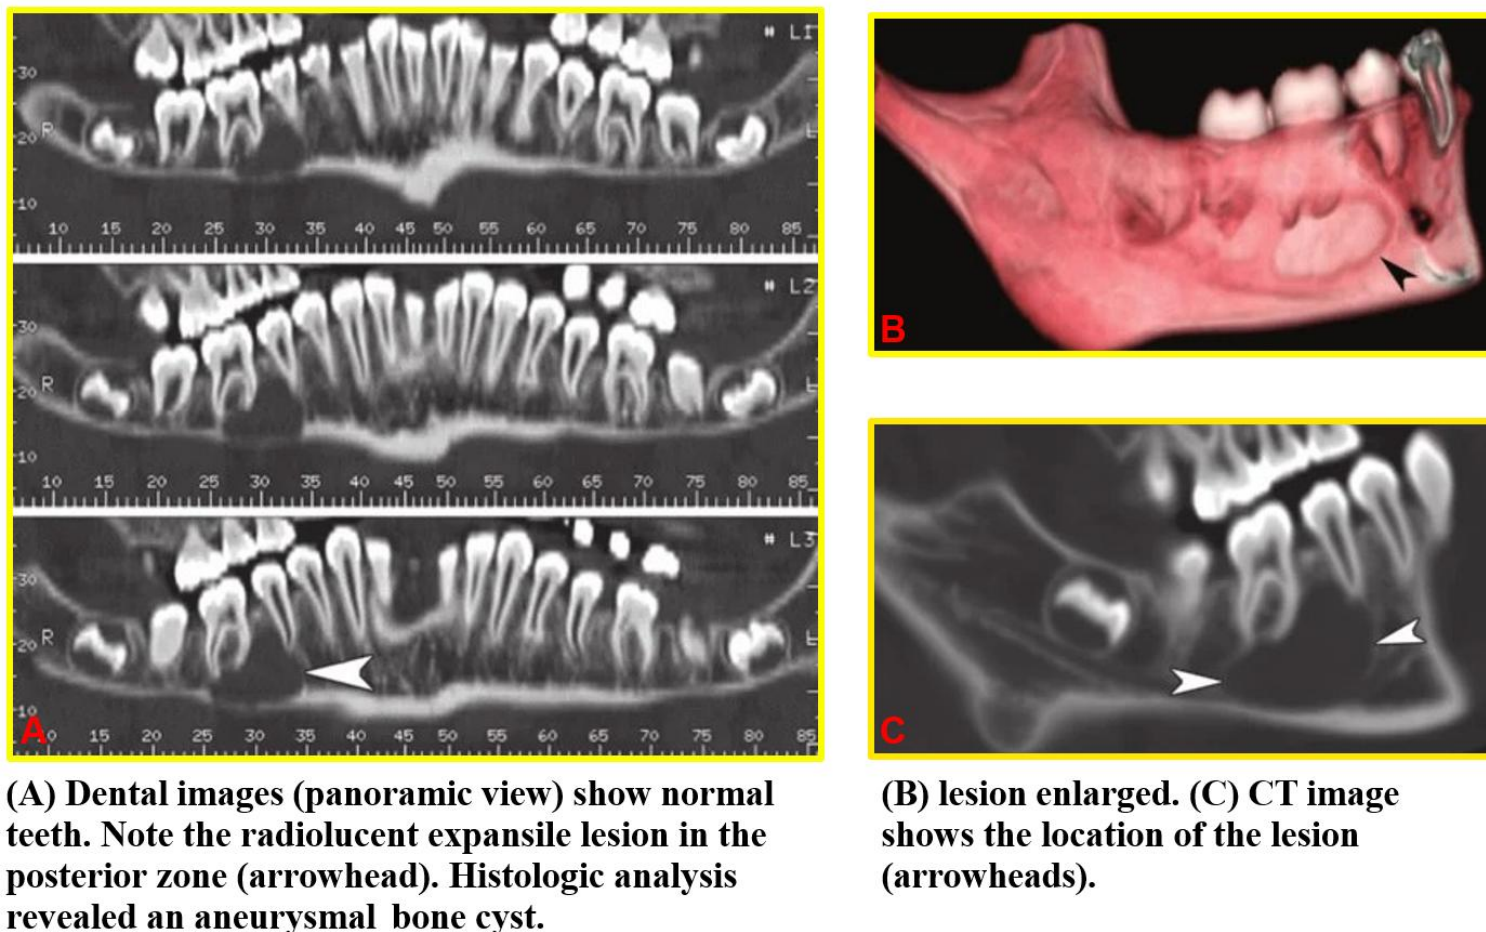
Uses of CT; appearance of teeth and periapical lesion (A - C).
